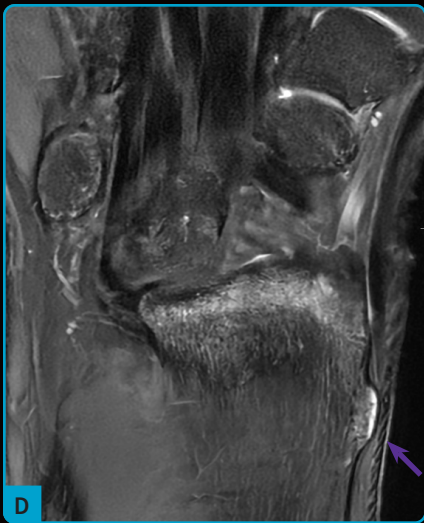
A 17-year-old patient presented with wrist trauma. Based on X-ray exam, patient was diagnosed with type I distal the radius epiphyseolysis and a cortical lesion in the distal diaphysis of the right wrist radius. MR confirms fracture without displacement of the distal radius with residual bone edema (red arrows) and osteochondroma in the distal radius metaphysis (purple arrows). The use of oZTEo and AIR™ Recon DL provided very high image quality, enabling assessment of both cortical bone and soft tissue in an good scan time. (A, B) Coronal T1 FSE with AIR™ Recon DL High 0.2 x 0.3 x 2.5 mm, 2:19 min.; (C, D) coronal Proton Density FatSat with AIR™ Recon DL High, 0.2 x 0.3 x 2.5 mm, 3:14 min.; (E-H) coronal oZTEo, 0.8 x 0.8 x 0.8 mm, 4:34 min.; and (I) axial oZTEo 0.8 x 0.8 x 0.8 mm, 4:34 min.
